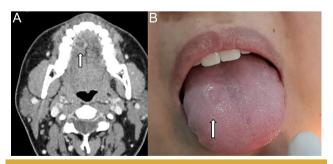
(A): Contrast-enhanced soft tissue window CT angiography showing a nodular image, well-circumscribed, with discrete areas of peripheral enhancement (arrow). (B): Tongue showing a light observable increase in volume (arrow). CT, computed tomography.
